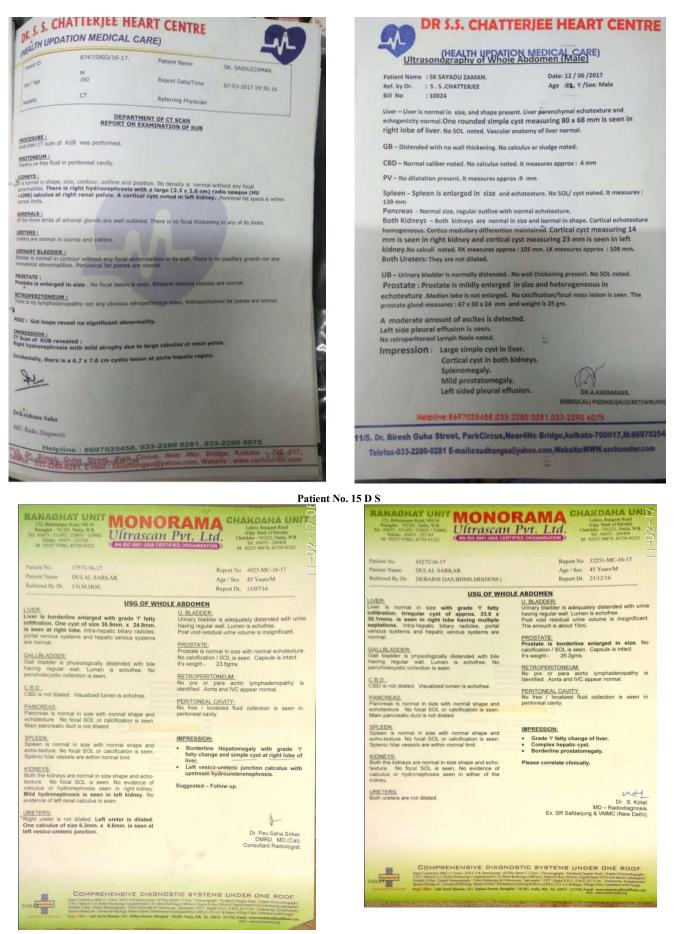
Ultra-sonographic reports of the patients showing removal of the stone(s).
